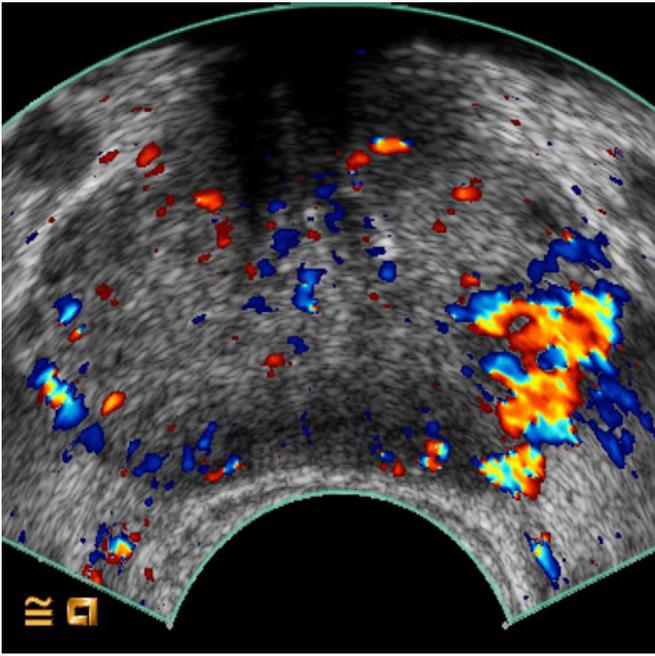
Transrectal contrast-enhanced colour Doppler ultrasound (CECD-US) shows an area with increased and asymmetric enhancement of colour flow signals on the left side of the PZ. A prostate carcinoma was confirmed by CECD-US targeted biopsy
